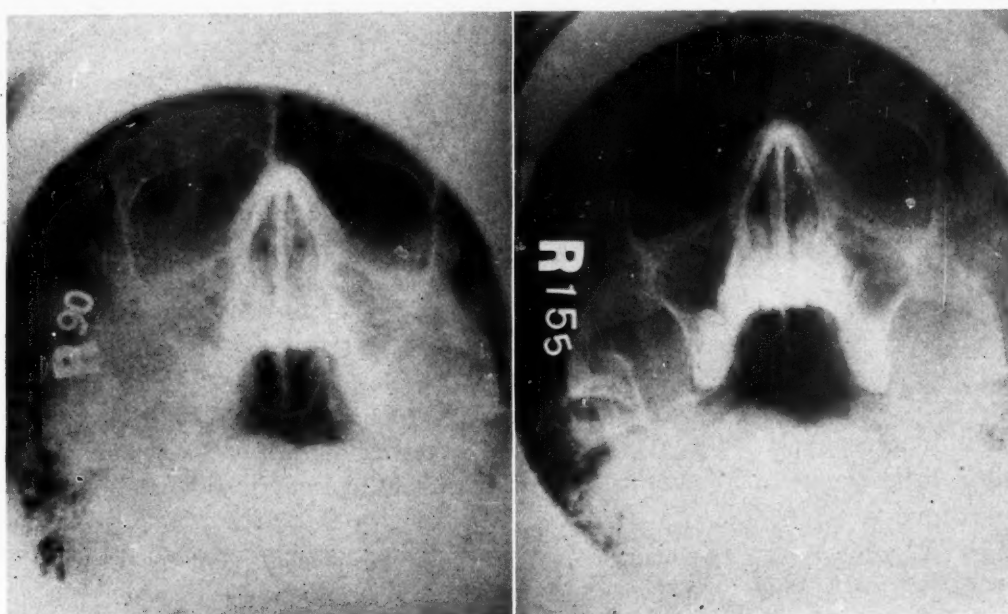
Sinus x-rays before second course of treatment (left) and after treatment (right) showing moderate clearing of both antra.
